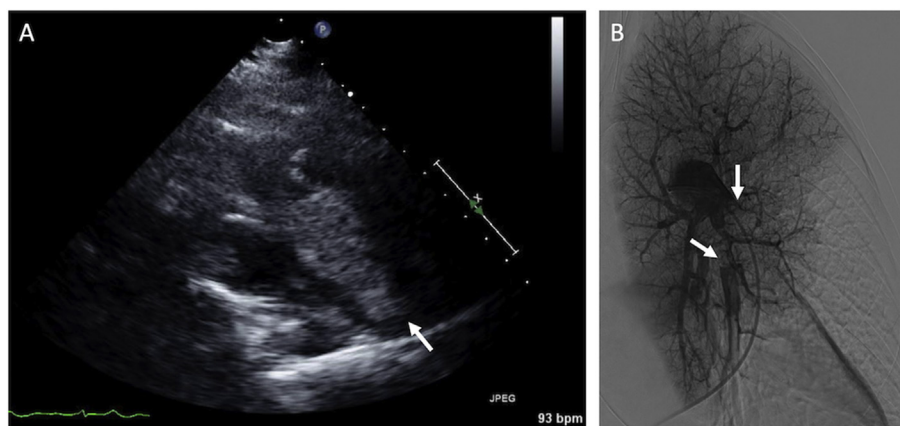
(A) Right atrial and ventricular clot burden shown by transthoracic echocardiogram. The transthoracic echocardiogram shows large mobile thrombi in the right atrium and ventricle (B) The left lung pulmonary emboli. Preliminary angiography showed thrombus within the left lower lobe segmental artery and lack of perfusion distally.
